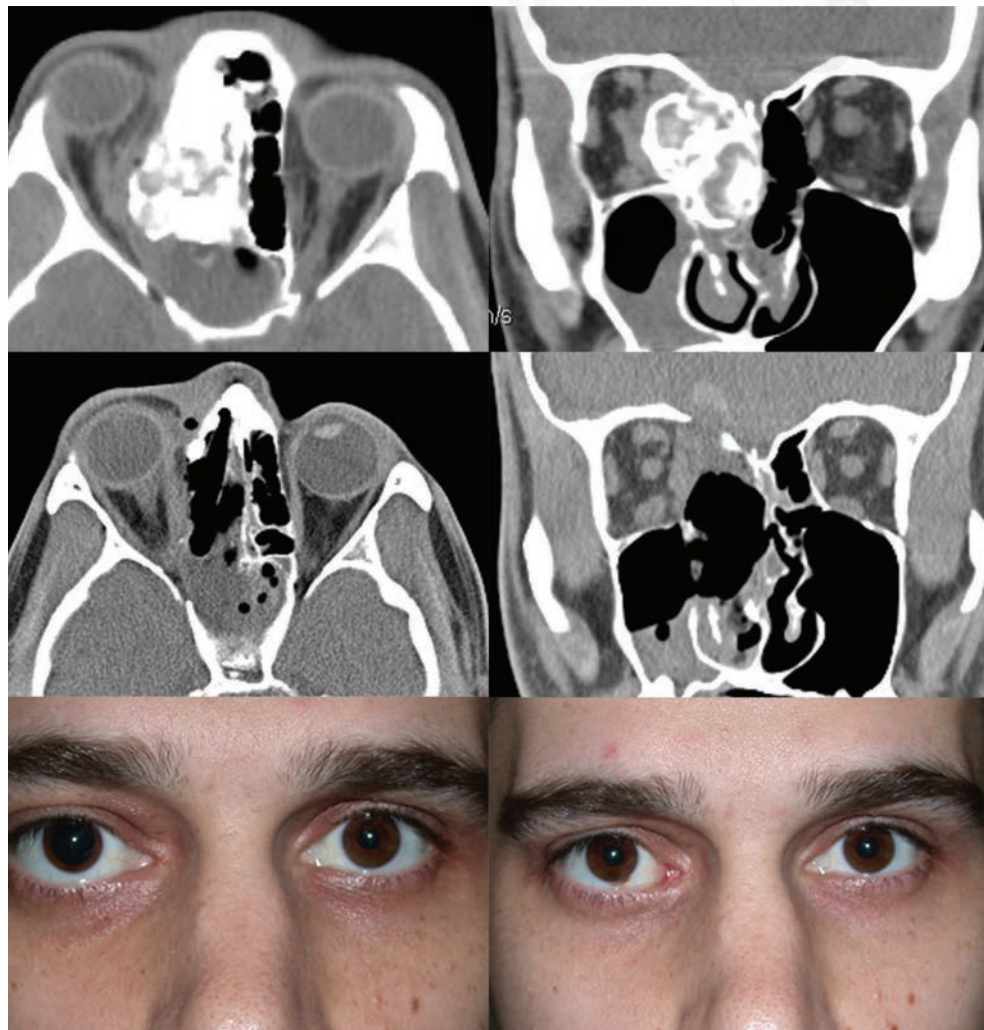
Top: CT scan of a 31-year old-man who presented with acute onset of diplopia and right proptosis. Imaging shows a large bony mass in the right ethmoid sinuses, orbit, and skull base. Middle: CT immediately following a combined transnasal endoscopic and transconjunctival extirpation of the tumor. The small hemorrhage in the gyrus rectus was asymptomatic. Bottom left: Preoperative appearance. Bottom right: 12 days postoperatively, the patient had improvement in proptosis, normal vision, and complete resolution of diplopia. The lesion proved to be an osteoblastoma.
